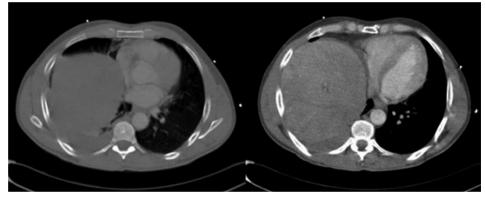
Computed tomography scan of the thorax, with and without iodinated contrast, showing elevation of the liver into the right hemithorax. In this case, diagnosis was confirmed by thoracoscopy prior to thoracotomy.
